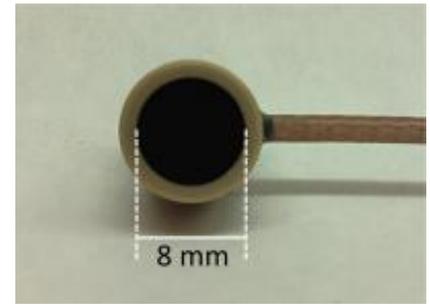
Close-up view of the 5MHz MR-compatible, single-element ultrasound transducer used here for hybrid data acquisition. While there was nothing special about the transducer itself or the MR images, correlations between the two offered interesting possibilities, such as scannerless synthetic MRI as demonstrated here.
